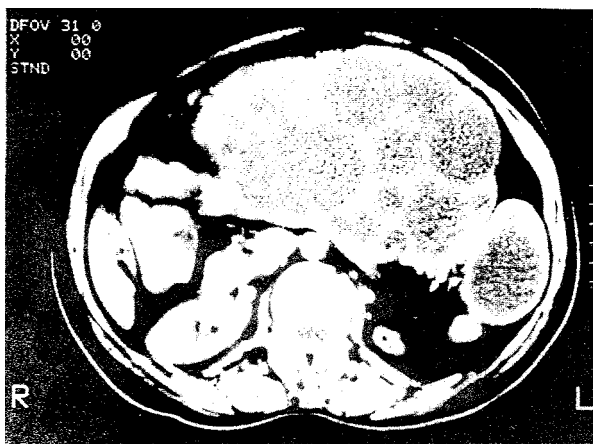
CT scan of the abdomen showing multivesicular hydatid cysts of liver, pancreas and spleen.
